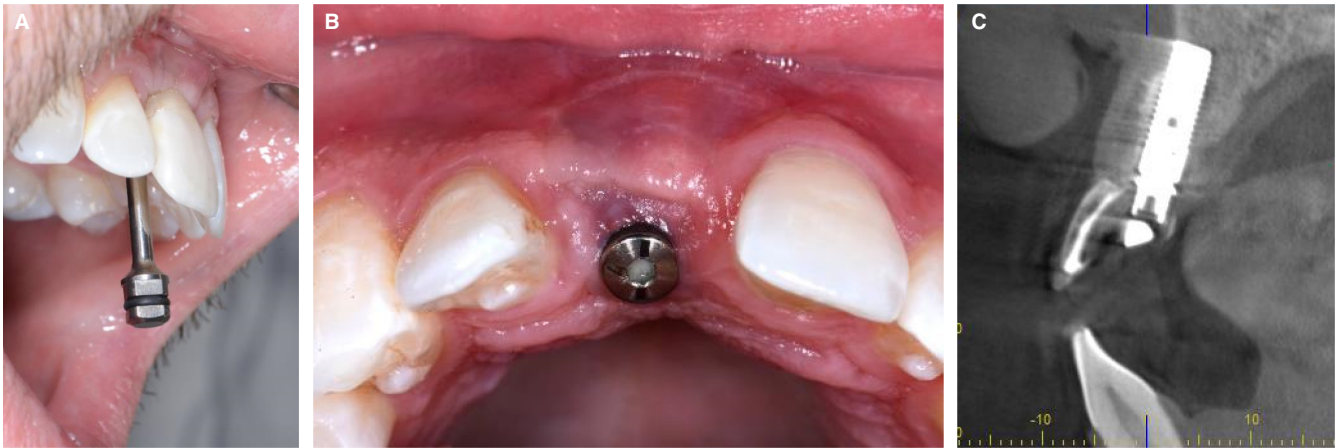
A, This implant in the upper right maxillary central incisor site has been placed in a palatal malposition. B, Following removal of the provisional crown, the palatal malposition can be observed clinically. There is also lack of tissue volume on the facial aspect. C, The CBCT scan confirmed the palatal malposition of the implant in relation to the axis of the provisional crown. Axially, the implant has also been tilted too far to the palatal side. CBCT, cone beam computed tomography
